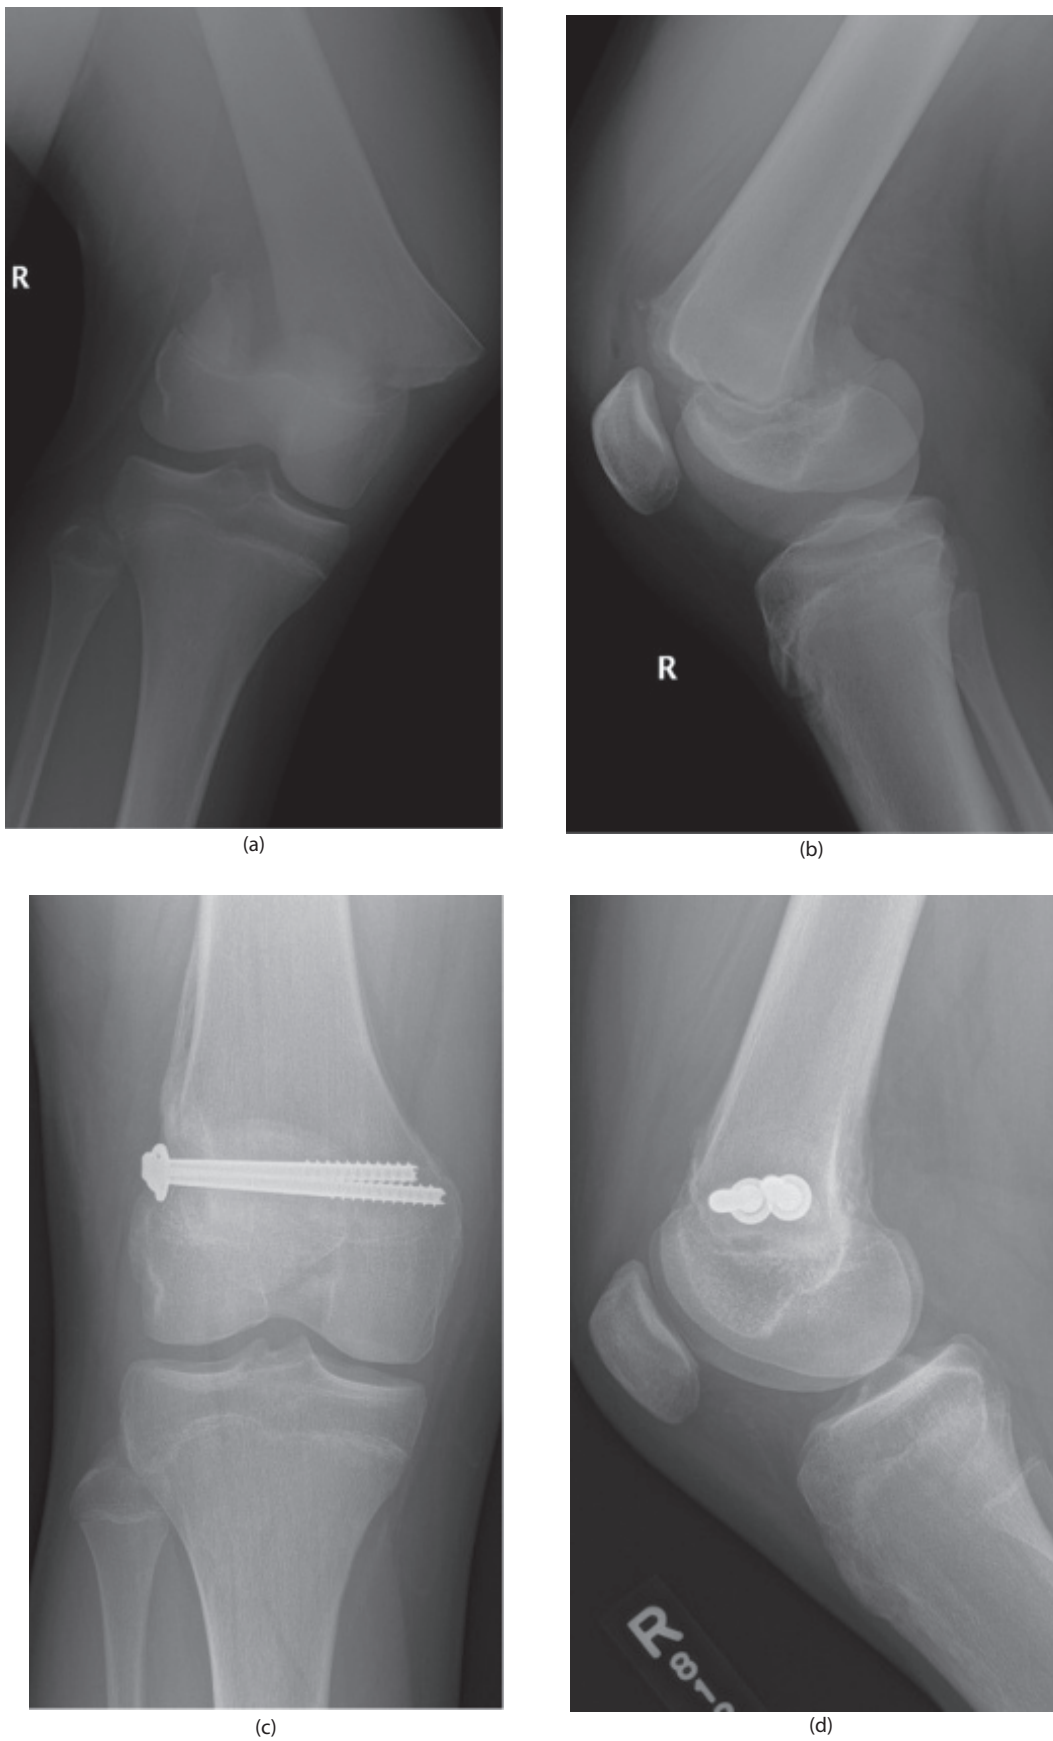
(a) and (b) Radiographs of a 15-year-old male who sustained a Salter-Harris II distal femur fracture while playing football. (c) and (d) The fracture was treated with open reduction and screw fixation.
